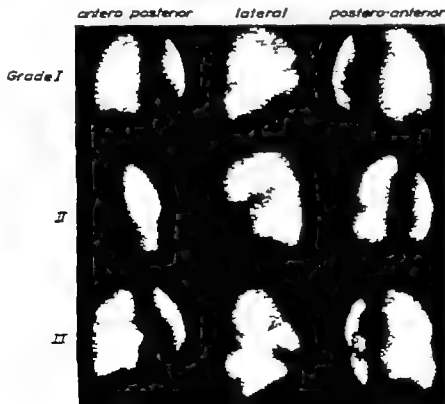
Grades of perfusion defects in the scintigrams.
